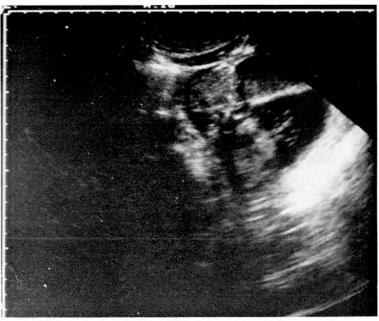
Sonographic examination of the pelvis (transverse scan). Large ovarian mass with some dense, hyperreflecting echoes inside (teeth).
